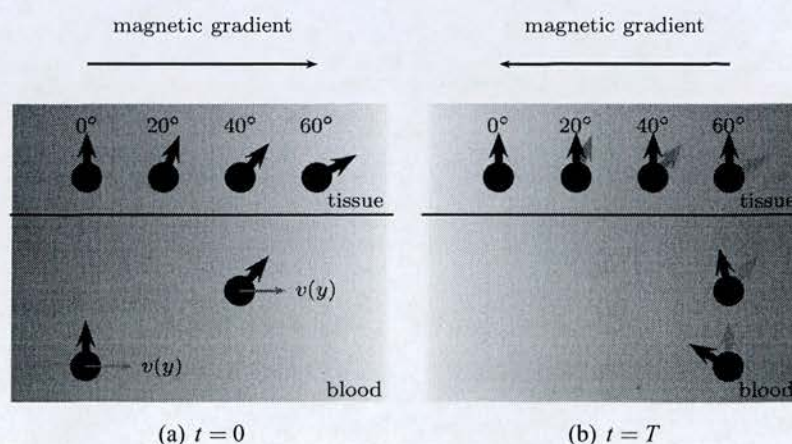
Velocity measurement using phase contrast MRI (adapted from similar figures in [97]).
